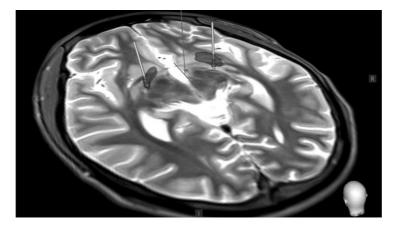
Deep brain stimulation implant bilaterally in the Gpi is demonstrated. The borders of the Gpi (blue color) were manually identified from 3T MRI images, and 3D reconstruction was generated using Medtronic SureTune 3 software (red color). Gpi, globus pallidum interna. Color images available online at www.liebertpub.com/cap
